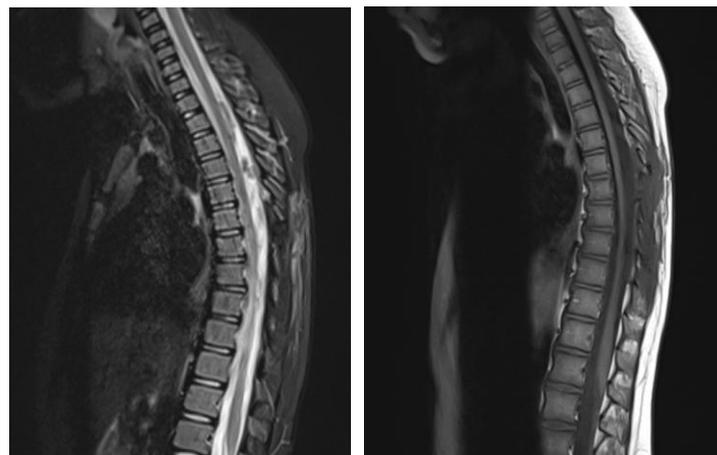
Spinal cord MRI in T1 and T2 sagittal slices showing total regression of the arachnoid cyst with evidence of musculoskeletal changes at the surgical site
